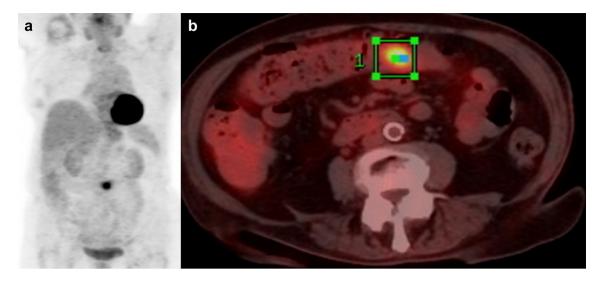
MIP- (a) and axial-fused PET/CT (b) images demonstrate a focal area of increased uptake (Max SUV=7.5, arrow) in the transverse colon. This represented an incidental finding in a patient
